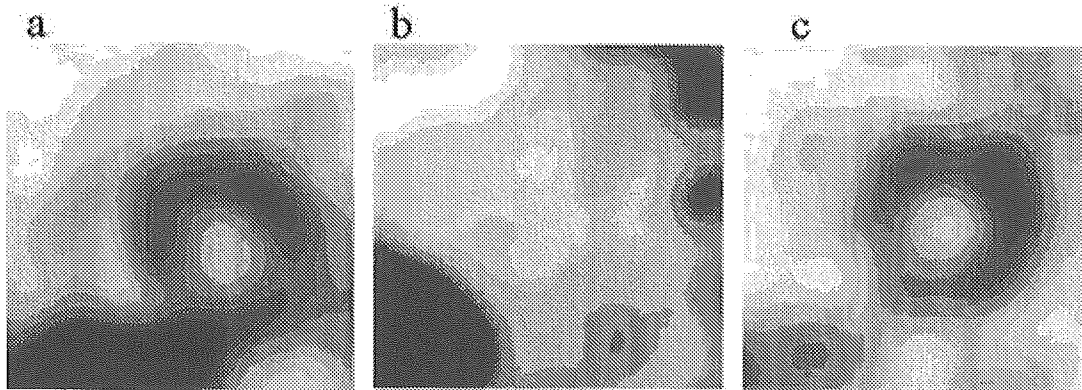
Short-axis views in the early phase of single-photon emission computed tomography of iodine-123-labeled metaiodobenzylguanidine (^{123}I -MIBG) myocardial scintigraphy in a 62-year-old man with autosomal recessive juvenile parkinsonism (a), a 58-year-old man with idiopathic Parkinson's disease (Hoehn and Yahr Stage II, b), and a healthy 62-year-old man (c).
